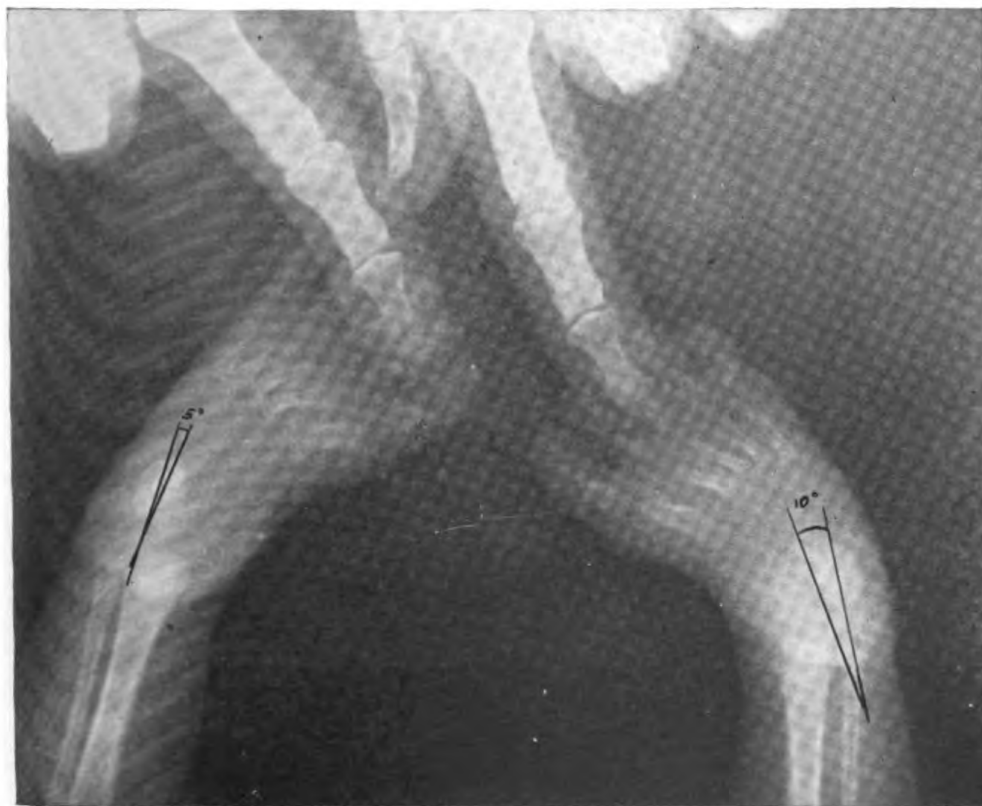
Roentgenogram taken at start of treatment.
